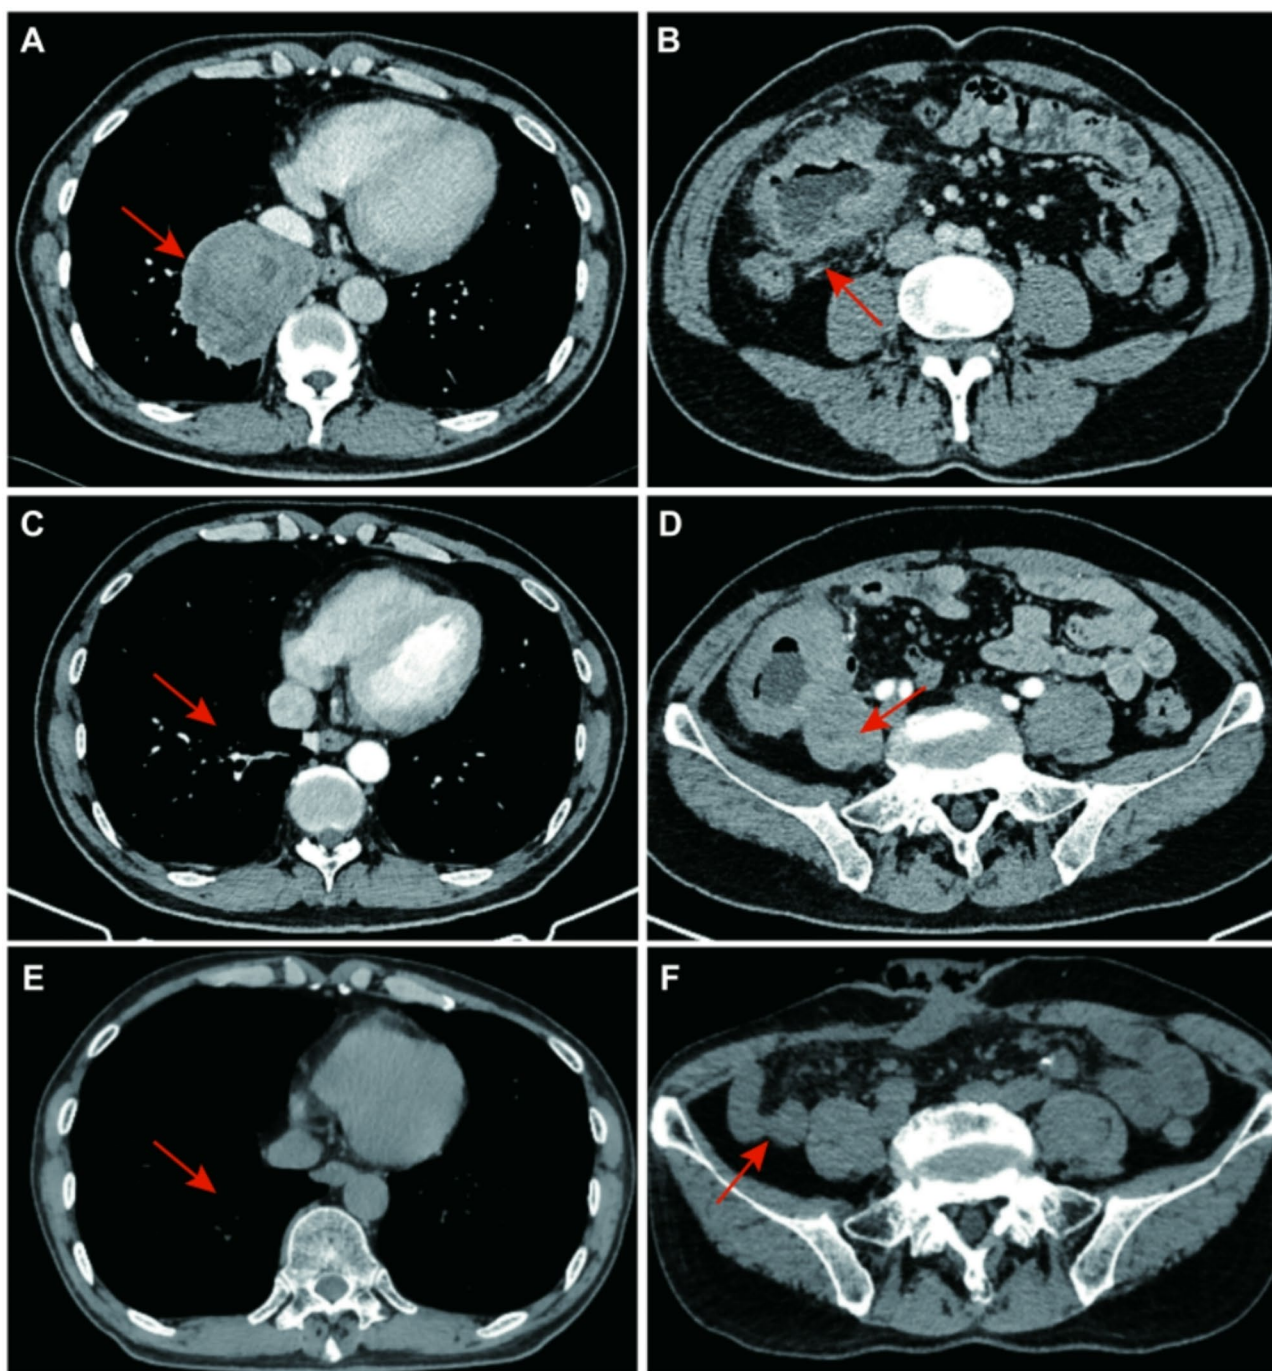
Imaging evaluation of the patient. A: Chest computed tomography (CT) scan before treatment. A mass measuring approximately 79 mm x 81 mm x 69 mm is seen in the basal segment of the lower lobe of the right lung as indicated by the arrow. It was slightly ill-defined with irregular lobulated margins and localized protrusion into the posterior mediastinum. B: Abdominal CT scan before treatment. There is marked thickening of the bowel wall and dilatation of the bowel lumen at the point indicated by the arrow. The surrounding fat interstitium is blurred with multiple lymph node shadows. C: Chest CT scan after 6 treatment cycles. The large mass in the basal segment of the lower lobe of the right lung, indicated by the arrow, has subsided and only a few irregular debris shadows are visible. D: Abdominal CT scan after 6 treatment cycles. The arrowed area shows localized thickening and abnormal enhancement of the small intestine in the right pelvis, suggesting recurrence of the intestinal tumor. E: CT scan of the chest at the end of treatment. The large tumor in the basal segment of the lower lobe of the right lung at the point indicated by the arrow has completely disappeared to a state of complete remission. F: CT scan of the abdominal at the end of treatment. The area indicated by the arrow is a postoperative change after small bowel perforation fistula. It shows a slight thickening of the intestinal wall at the anastomosis site, with no obvious features of tumor involvement
